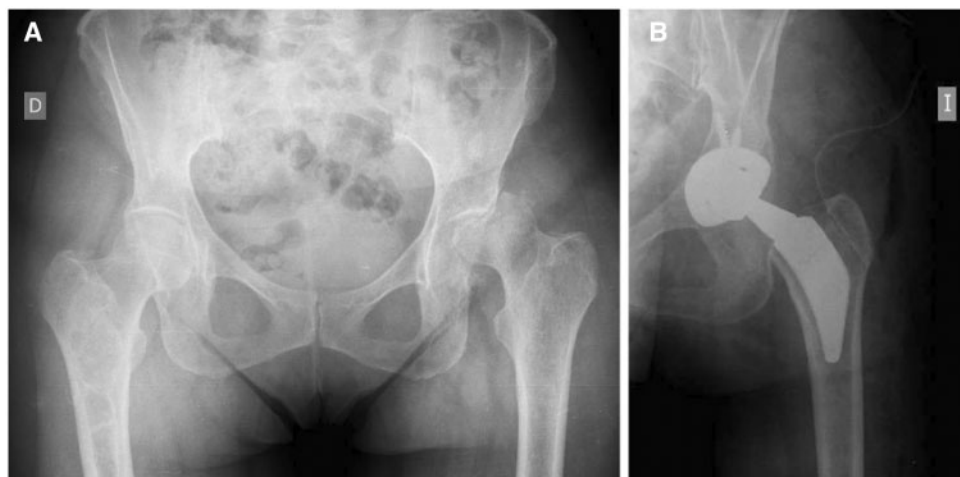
(A) Antero-posterior hip radiography performed 8 weeks after labral reconstruction, showing a collapse of the femoral head. (B) Antero-posterior hip radiography in which the total hip arthroplasty with a short stem performed after collapse of the femoral head can be observed.
